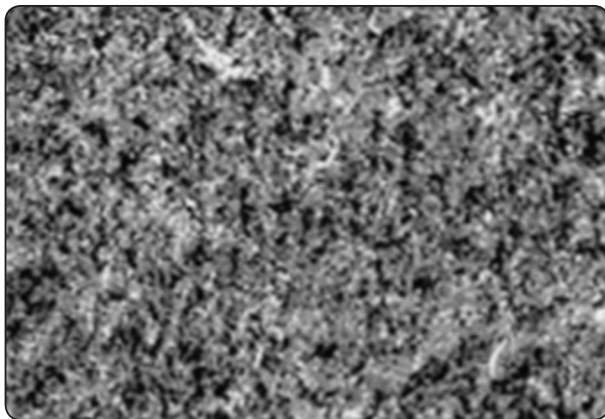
SEM of CT silica-coated zirconia surface before cementation
